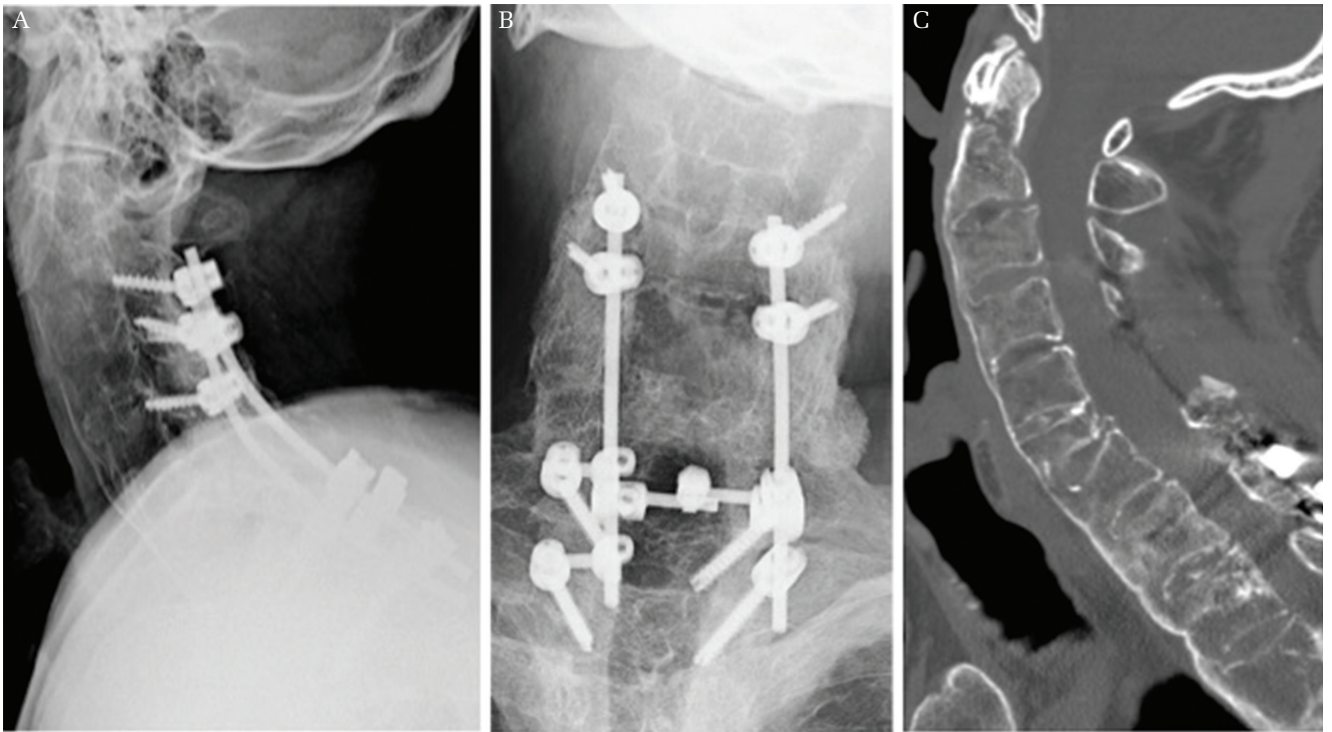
Case 1. Postoperative plain radiography (A and B) and computed tomography scanning 6 months after surgery (C) show a bony union.
